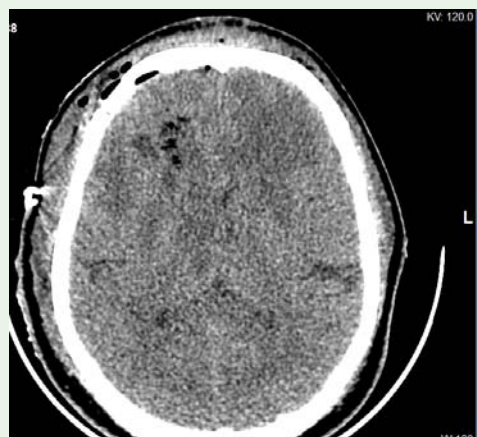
Follow-up CT scan brain 10 days (Before surgery) after abscess drainage.
